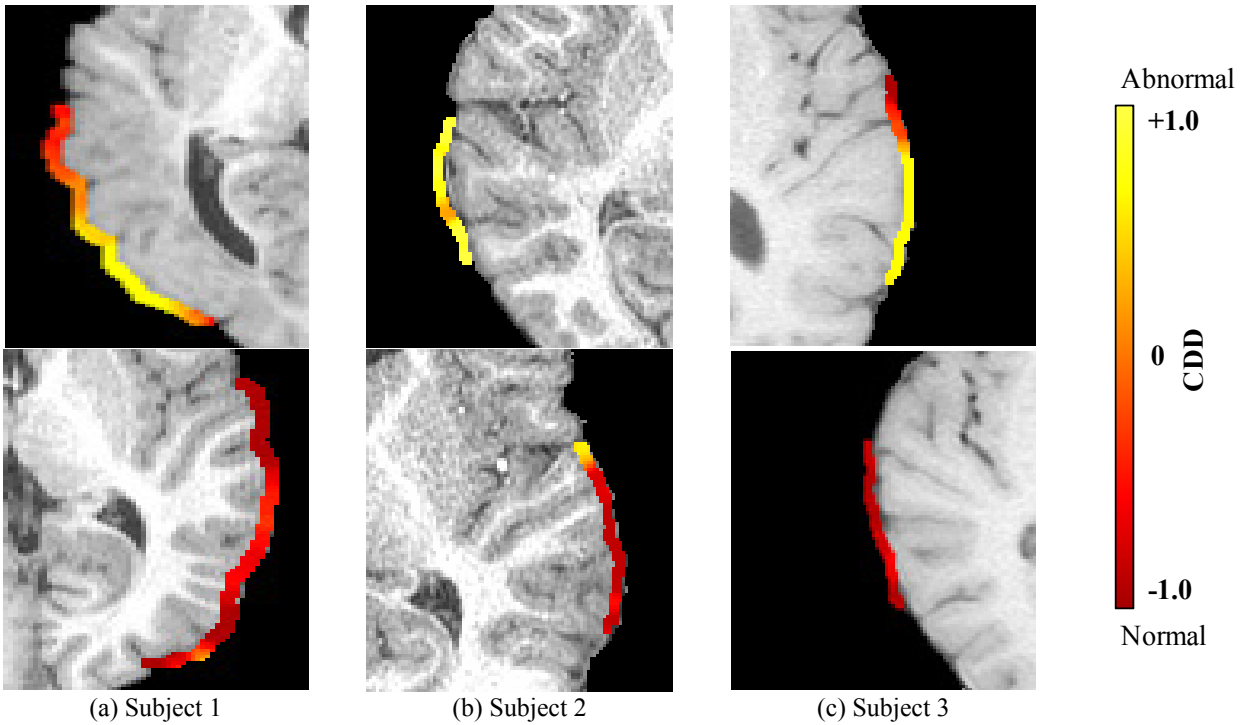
Experimental results of the learning capability test. Upper images show the CDD map around the cortical dysplasia lesion, and lower images show the CDD map around the healthy region, superimposed on the raw MR images.
